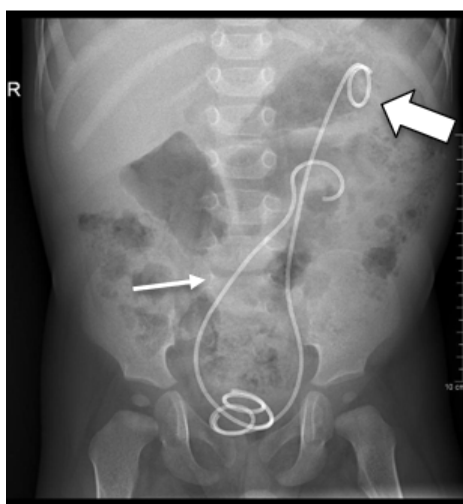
An abdominal X-ray demonstrating the right double J stent traversing the midline and extending toward the anatomical location of the left kidney (white small arrow). The left Double J stent can be seen extending to the location of the superiorly displaced orthotropic left kidney (white thick arrow).
